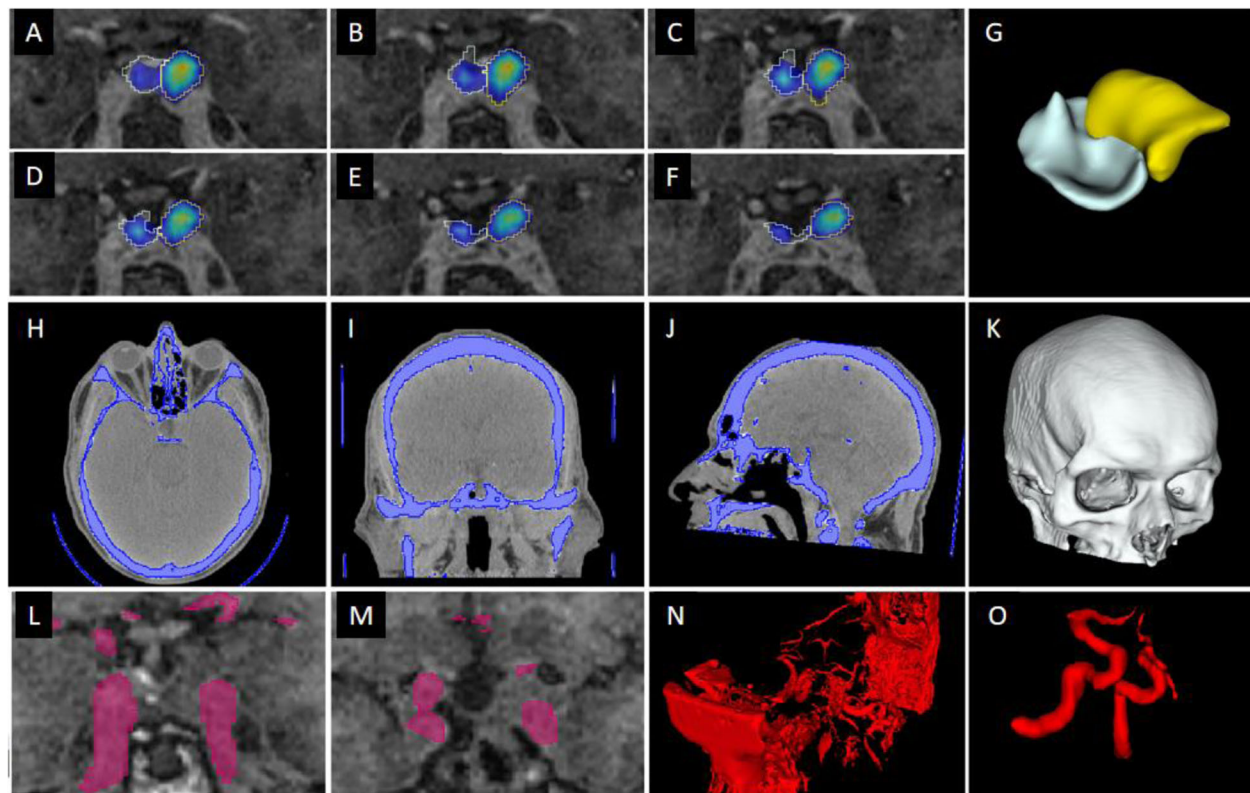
Segmentation of the pituitary gland and adjacent structures. A–F, Pituitary gland (blue) and pituitary tumor (yellow) segmentation using PET registered with MRI. G, 3D rendered model of pituitary gland (white structure) and pituitary tumor (yellow structure). H–J, Bone segmentation from CT using thresholding tool. K, 3D rendered model of bone after removal of small islands and imaging bed. L–M, Carotid arteries segmentation with FSPGR MR using thresholding tool. N, Initial 3D rendered segmentation of MR soft tissue. O, Final segmentation of carotid arteries after unwanted structures have been removed
